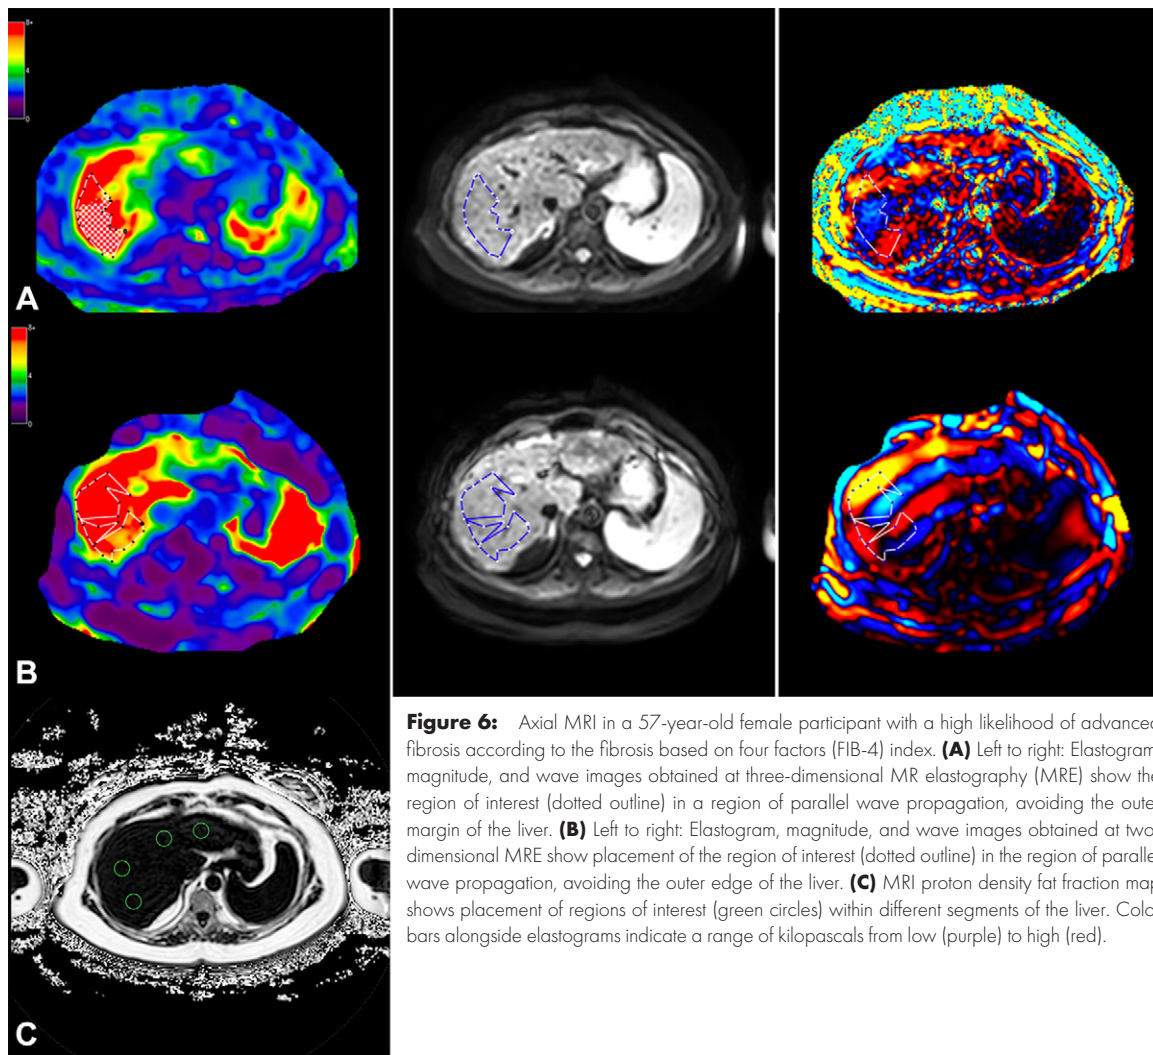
Axial MRI in a 57-year-old female participant with a high likelihood of advanced fibrosis according to the fibrosis based on four factors (FIB-4) index. (A) Left to right: Elastogram, magnitude, and wave images obtained at three-dimensional MR elastography (MRE) show the region of interest (dotted outline) in a region of parallel wave propagation, avoiding the outer margin of the liver. (B) Left to right: Elastogram, magnitude, and wave images obtained at two-dimensional MRE show placement of the region of interest (dotted outline) in the region of parallel wave propagation, avoiding the outer edge of the liver. (C) MRI proton density fat fraction map shows placement of regions of interest (green circles) within different segments of the liver. Color bars alongside elastograms indicate a range of kilopascals from low (purple) to high (red).
